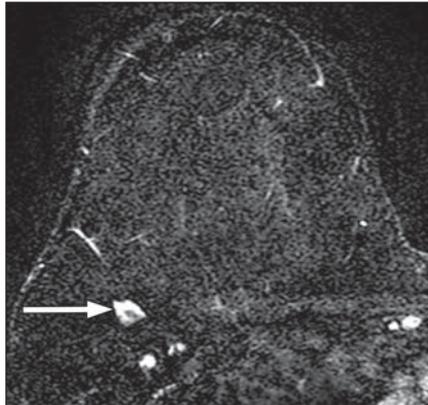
Oil cyst associated with fat necrosis in 56-year-old woman with history of breast cancer and fat transfer in both breasts. A and B, MR images show well-circumscribed round mass with central high signal intensity (*arrow*) on T2-weighted image (A) and loss of signal intensity on fat-suppressed contrast-enhanced image (B), with thin rim of smooth enhancement.
